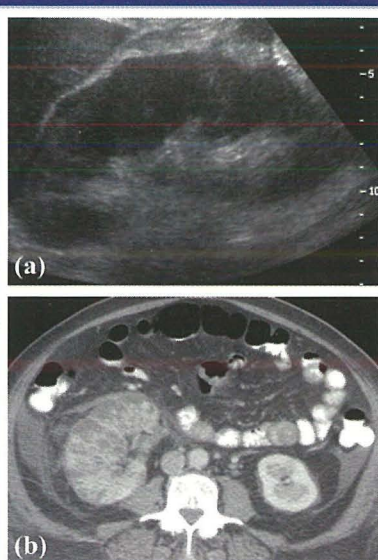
(a) US image demonstrates a slightly enlarged right kidney that is otherwise unremarkable, belying the advanced disease. (b) CT scan shows the enlarged kidney with multiple small low-attenuation foci from abscess pockets, findings that prompted nephrectomy.
